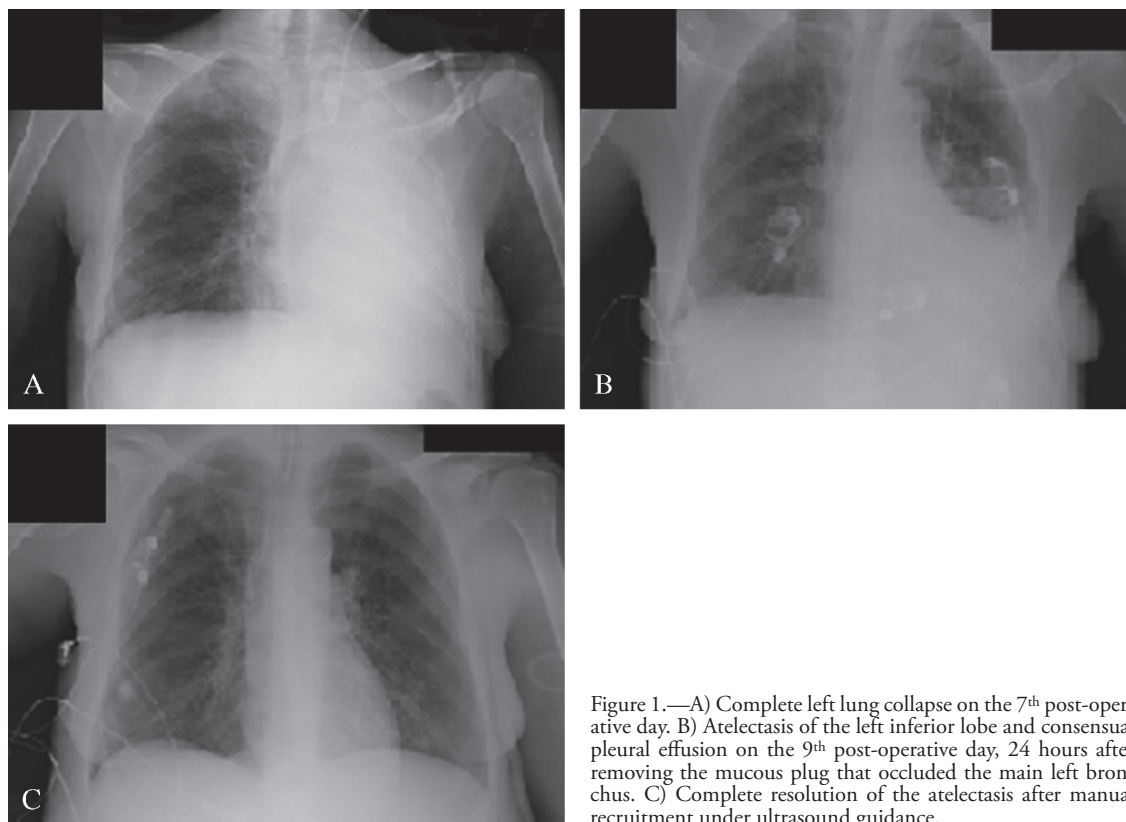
A) Complete left lung collapse on the 7th post-operative day. B) Atelectasis of the left inferior lobe and consensual pleural effusion on the 9th post-operative day, 24 hours after removing the mucous plug that occluded the main left bronchus. C) Complete resolution of the atelectasis after manual recruitment under ultrasound guidance.
